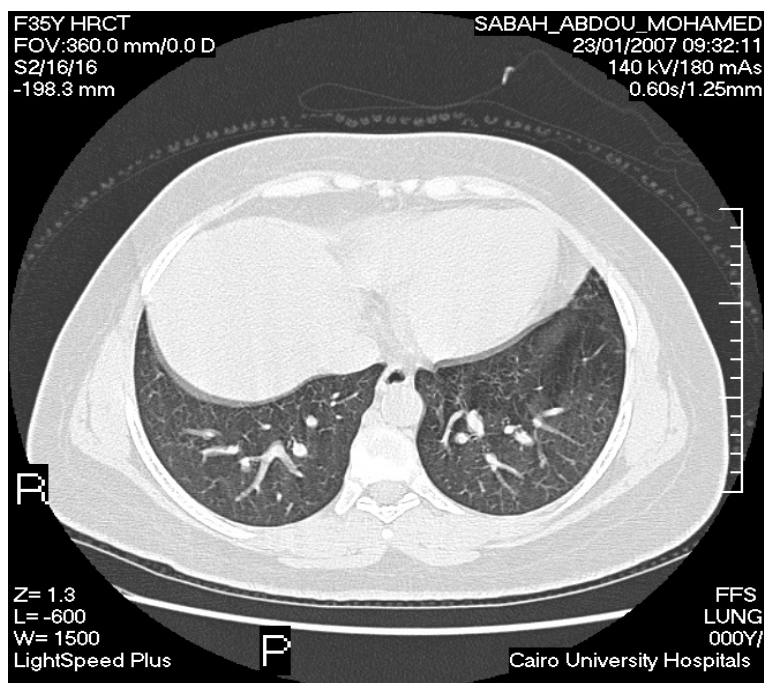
HRCT chest of case (no.18) A 32 year old female patient with HCV infection, non smoker. He had no chest complaint. This cut of HRCT revealed groundglass attenuation in the left lower lung zone. The rest of the cuts showed anterior right lower zonal atelectatic band. She took a score of 3.
